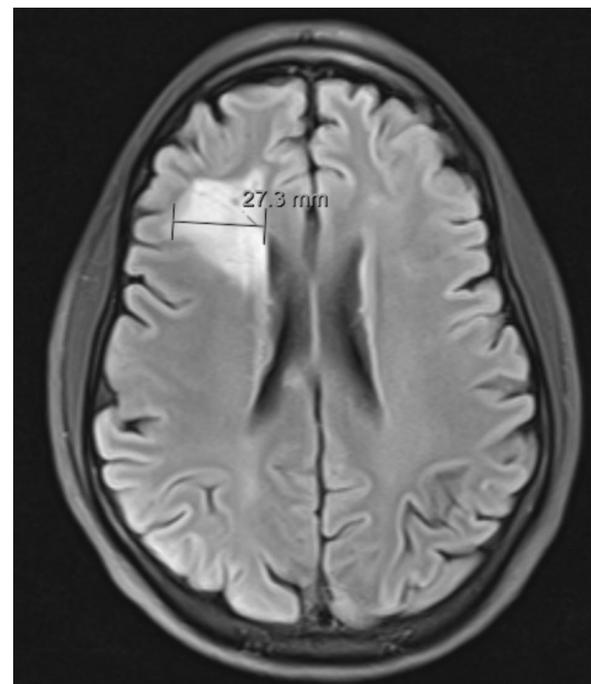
T2 FLAIR MRI brain showing right frontal lobe hyperintensity.
